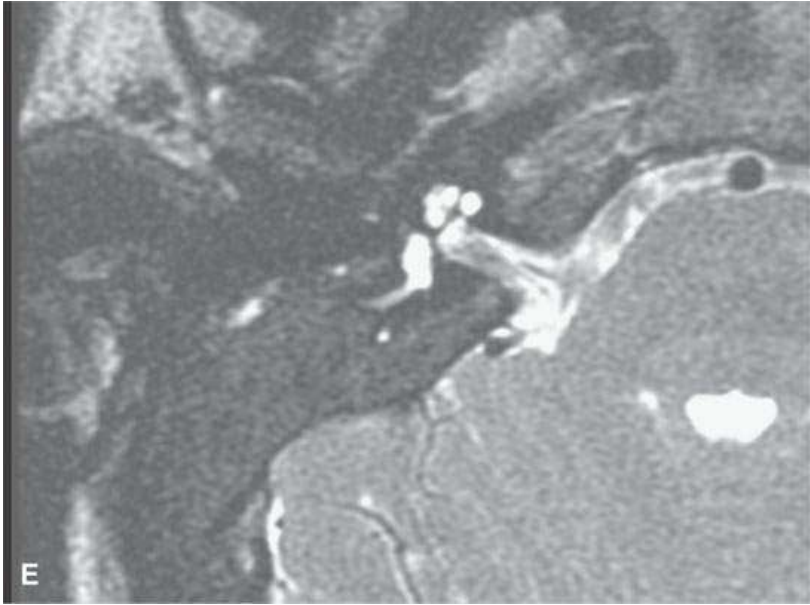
Fibrous dysplasia of the temporal bone—a simple diagnosis on computed tomography (CT) but more complex and less “recognizable” as such on magnetic resonance imaging (MRI). A, B: CT showing typical fibrous dysplasia in a somewhat atypical location—the petrous part of the temporal bone. T1-weighted contrast-enhanced axial (C) and coronal (D) MRI showing low-grade enhancement that appears to be beyond the expected margin of bone (*arrows*), but the bone is actually “expanded.” The T2-weighted MRI shows low signal of the involved bone, suggesting a fibrous, or at least relatively proton poor or poorly mobile proton, environment in the lesion.
